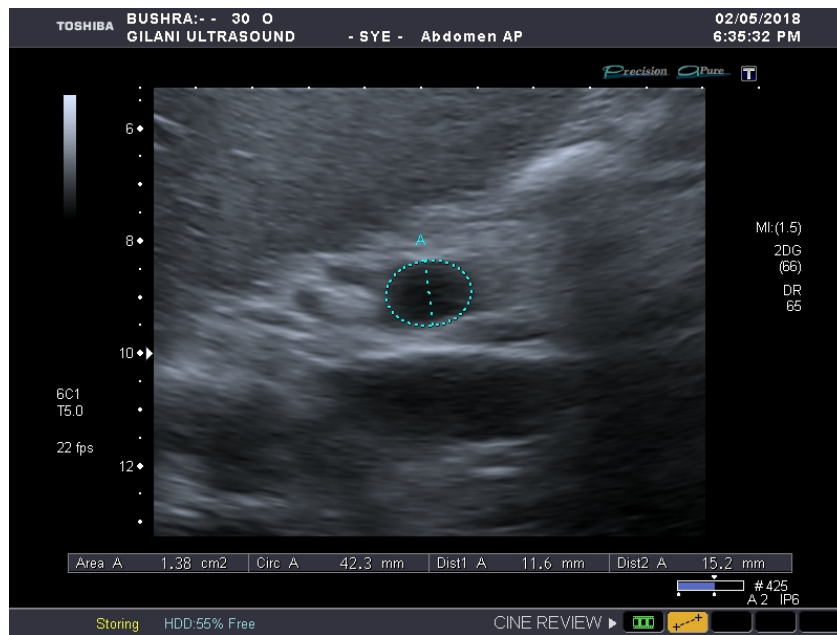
Ultrasound Image showing increased portal vein diameter in CLD.
